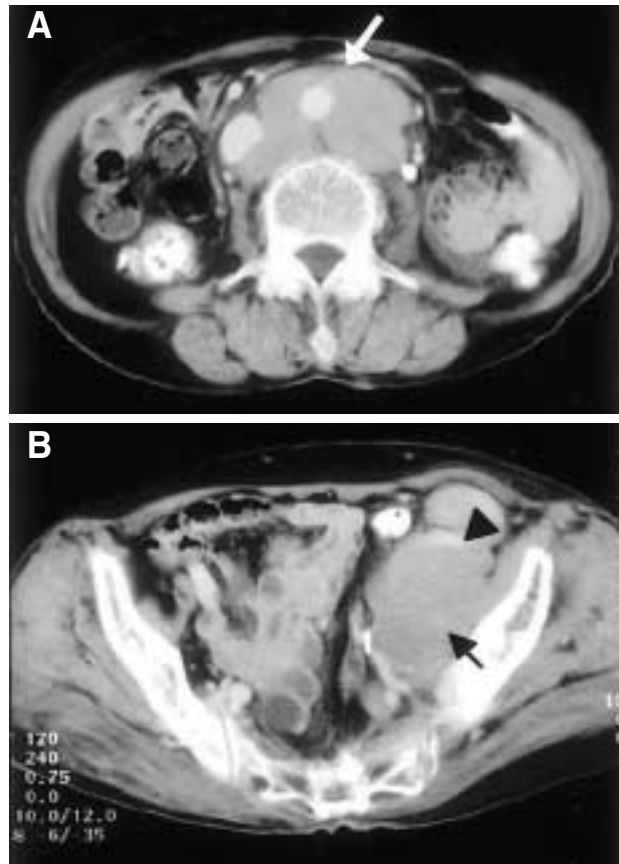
(A) Contrast enhanced CT scan showing well-defined, conglomerated, hypodense masses (arrow) around both para-aortic areas. (B) Hypodense, well-defined masses (arrow) were noted at the left side pelvic cavity, displacing the left distal ureter medially. Arrowhead: left external femoral vein.
